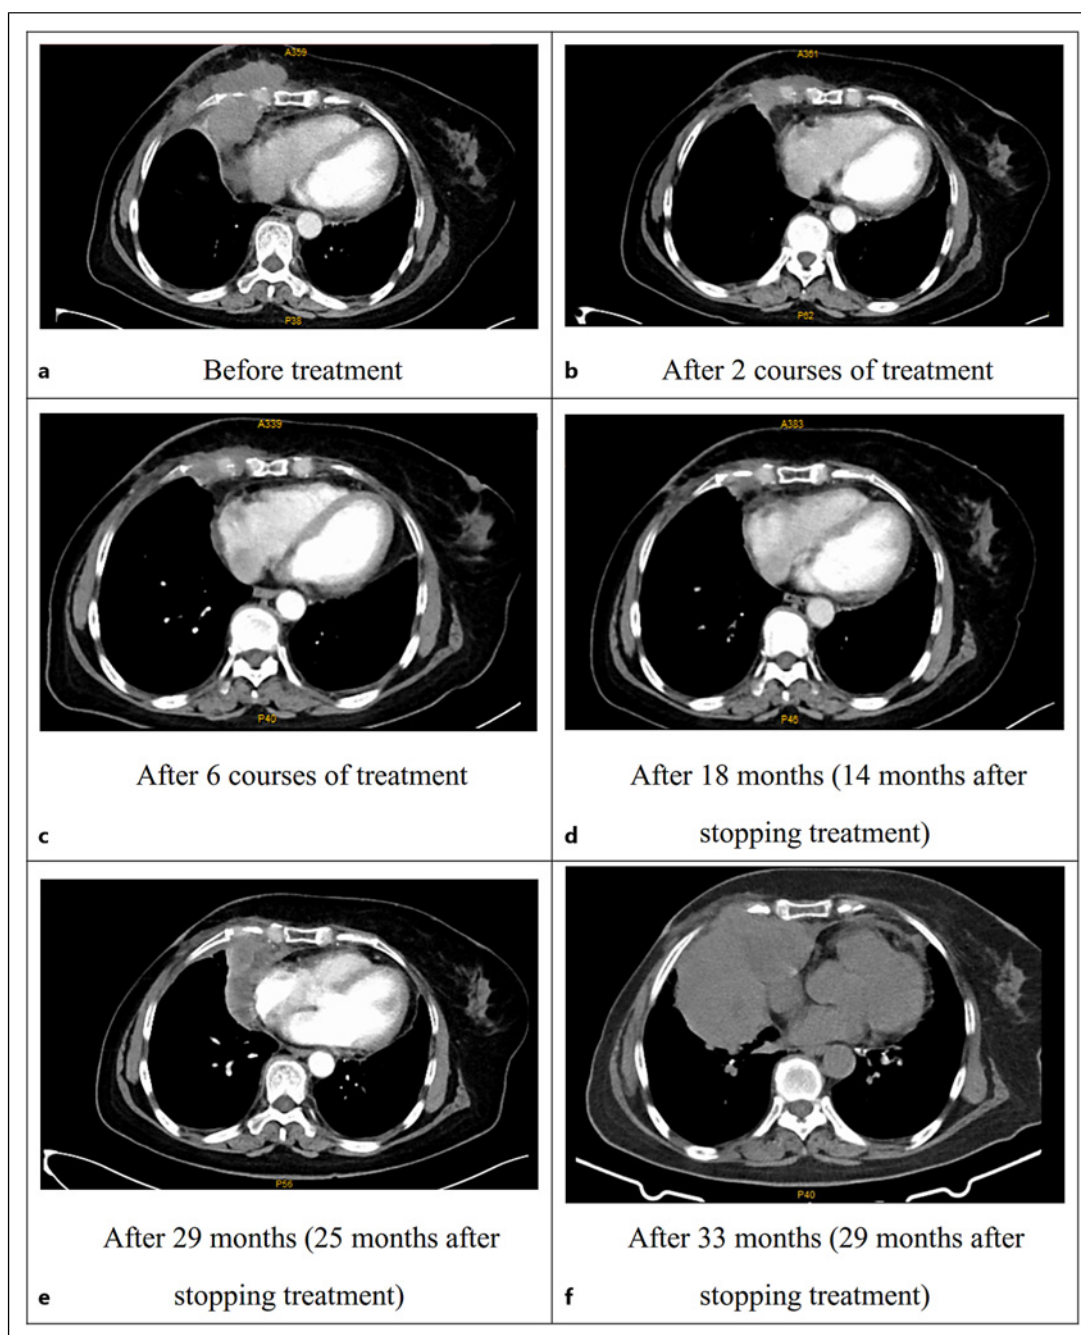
a–f Comparison of chest CT in different treatment periods.
